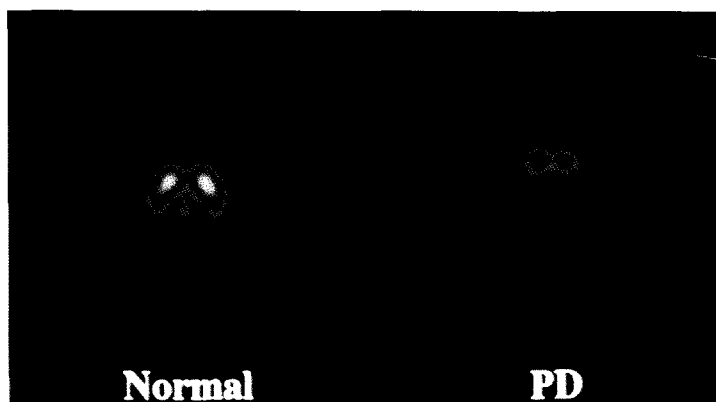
[¹²³I]β-CIT SPECT images of a healthy subject and of a Parkinson's disease (PD) patient. In the patient with PD, [¹²³I]β-CIT binding in the striatum is markedly reduced; a greater reduction occurred in the putamen than in the caudate.
